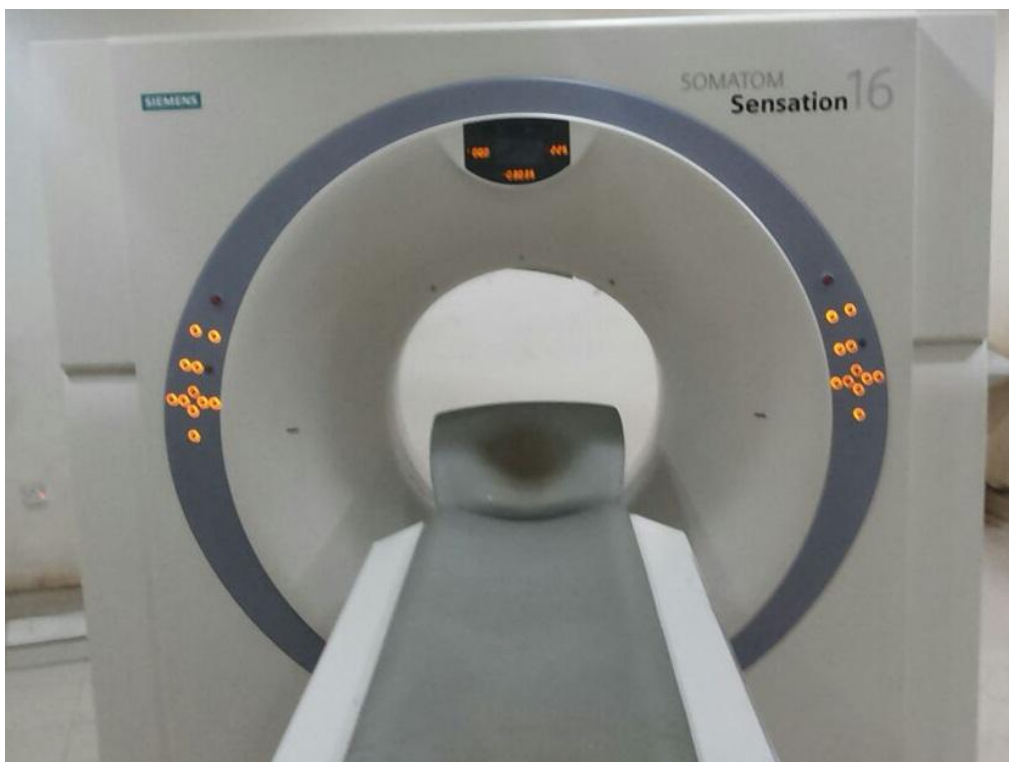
Siemens CT scanner Germany16 slice
